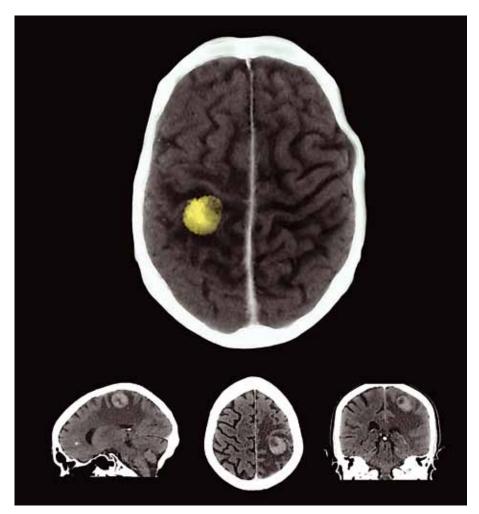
CT scan of the brain showing a large metastasis
